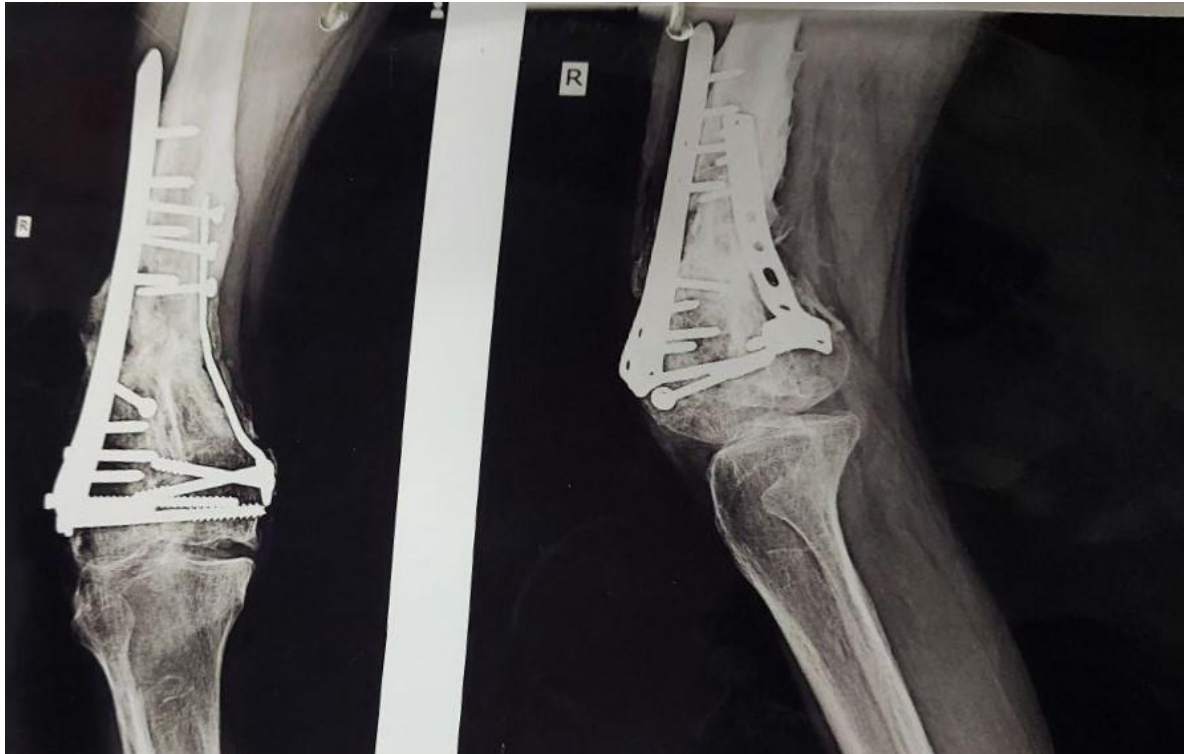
Showing X-ray of patient's right knee
